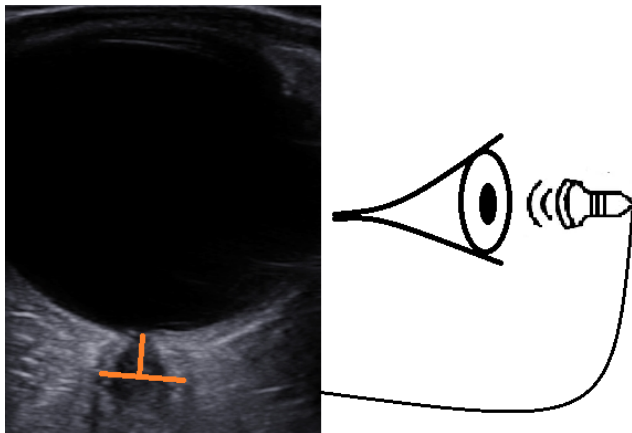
Demonstration of ultrasonographic measurement of ONSD measurement.
